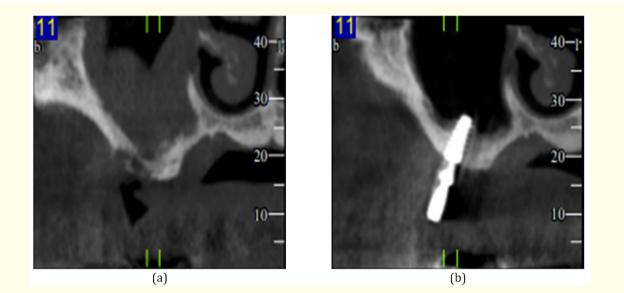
CBCT scan before (a) and after rehabilitation (b). Full bone regeneration in height and around Implant.
